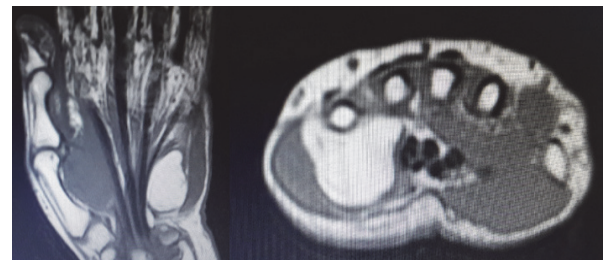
Axial and coronal sections of MRI, showing the palmar mass surrounding metacarpal 5.
